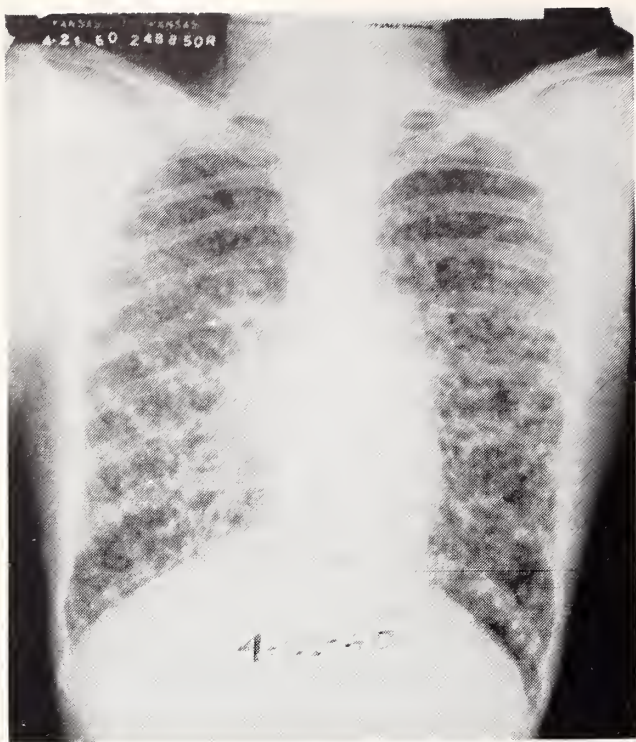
Case 1. Chest x-ray consistent with metastatic carcinoma of the thyroid, April, 1960.
